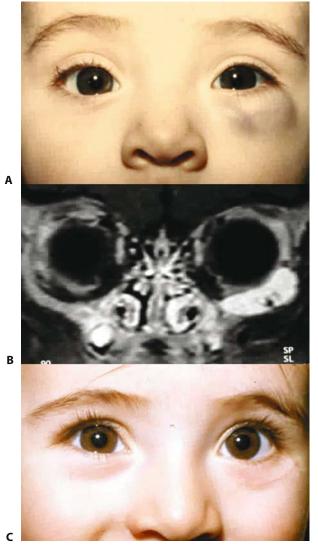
One-year-old boy with a capillary hemangioma involving the left inferior orbit. (A) Facial photograph showing bluish discoloration, swelling of the left lower eyelid, and upward displacement of the eyeball by the inferiorly located orbital capillary hemangioma. (B) T1-weighted coronal MR image demonstrating the inferiorly located capillary hemangioma with marked contrast enhancement. Note the signal-void areas representative of high flow vessels. (C) Postoperative facial photograph 6 months after excision of the lesion. There is no superior displacement of the globe.
